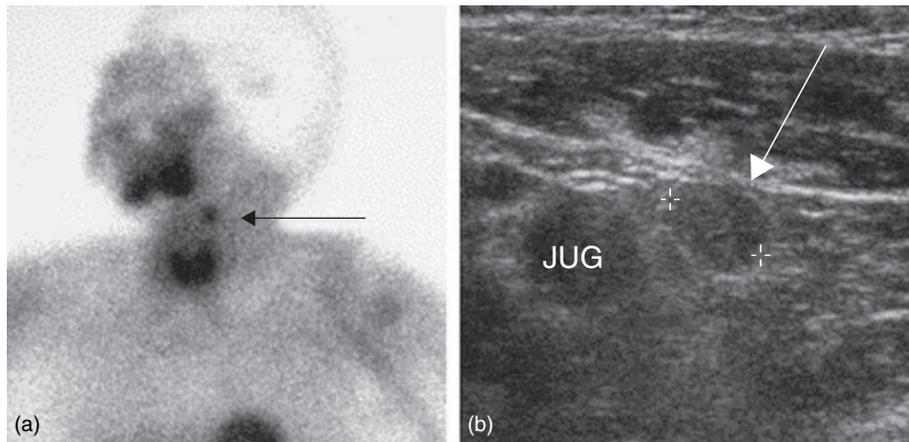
The use of dual modality to identify parathyroid gland. (a) Planar Sestamibi of left lateral neck. (b) Transverse ultrasound of left neck. JUG, jugular vein; arrow.
